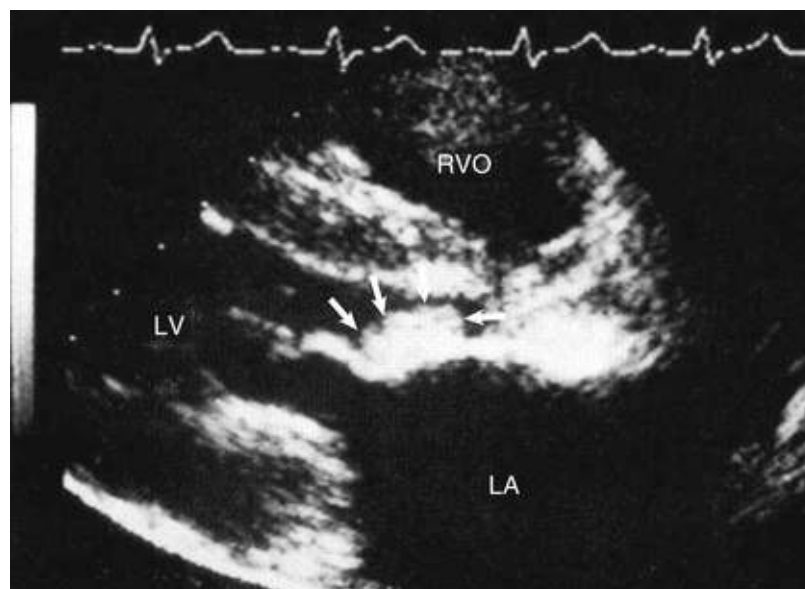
Parasternal long-axis view of the heart from a patient with SLE and high-titer antiphospholipid antibodies. A massive vegetation is seen on the ventricular surface of the anterior mitral leaflet (*arrows*), but it is not interfering with valve mobility. *LA*, left atrium; *LV*, left ventricle; *RVO*, right ventricular outflow. (Courtesy Professor Petros Nihoyannopoulos, National Heart and Lung Institute, Imperial College, London.)
